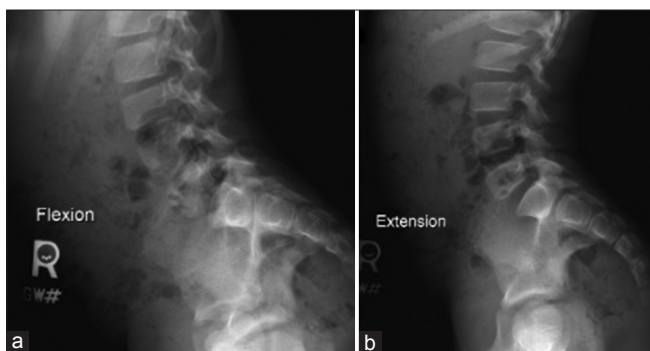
Flexion (a) and extension (b) X-rays revealing no abnormal motion at L5-S1.
